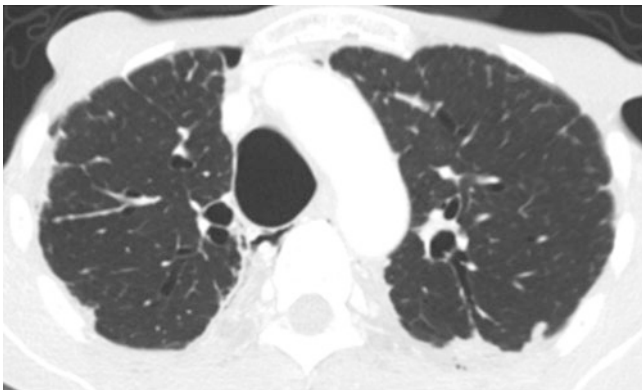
A CT scan of the chest of a 66-year-old man with tracheobronchomegaly. The anteroposterior diameter is 37 mm
